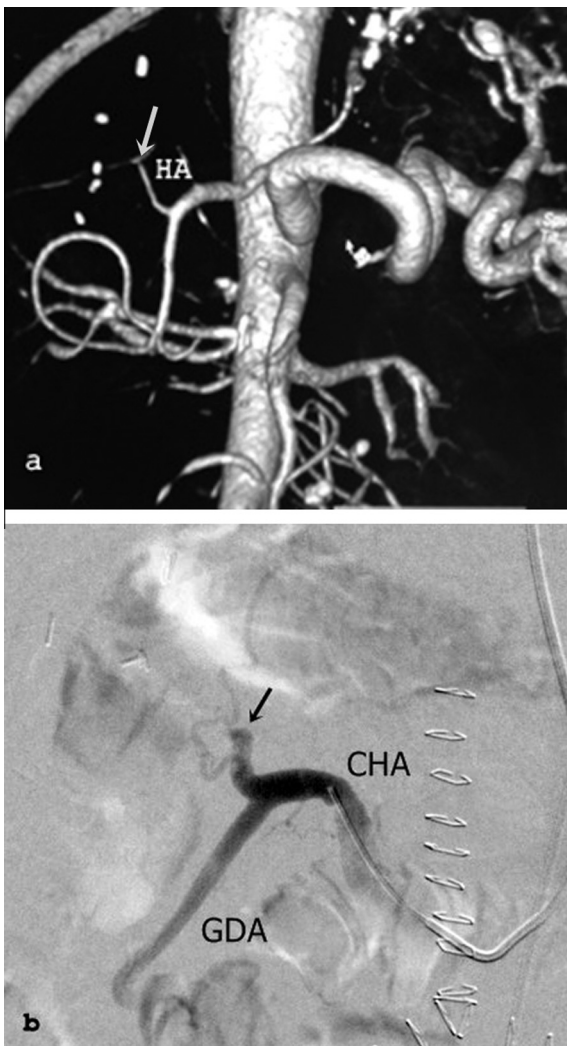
Fifty-six year old male recipient 4th day post LDLT with stable liver enzymes and absent hepatic artery flow on Doppler US. (a) Coronal CT angiography VR image shows occluded HA proper just proximal to the anastomosis (white arrow). (b) Selective hepatic arteriogram image confirmed HAT with absent intrahepatic flow.
